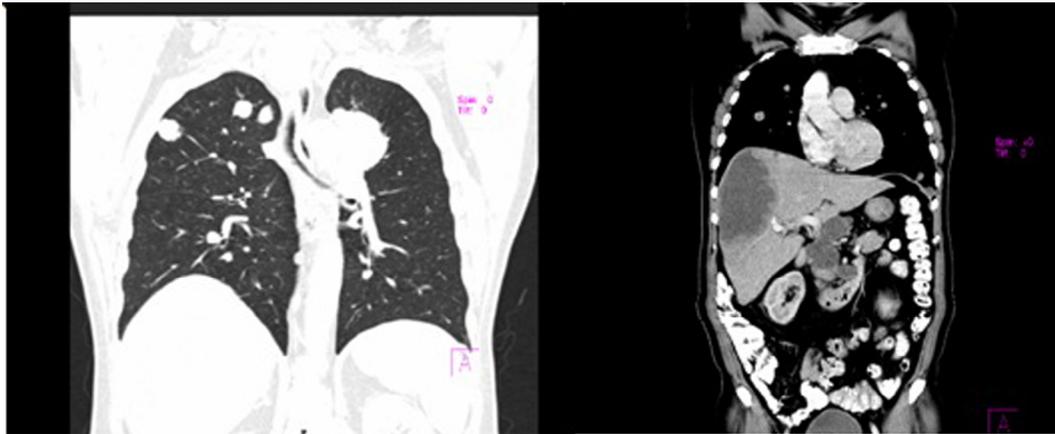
Whole body CT scan showed disseminated metastatic deposits in liver, lung and retroperitoneum.
